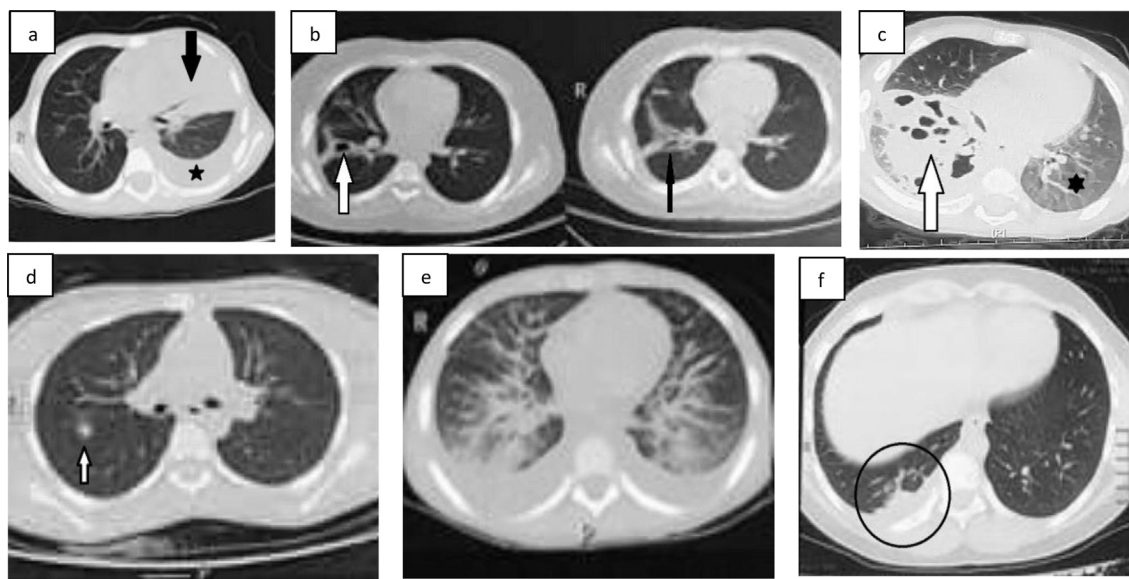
Atypical CT scan findings: a) complete lobar consolidation in left upper lobe (arrow) with left side pleural effusion (asterisk); b) A small cavity (arrow) with adjacent consolidation (thin solid arrow) in right lower lobe, c) A large area of cavitation/bronchiectasis with surrounding consolidation in right lower lobe (arrow). Diffuse ground glass opacity (asterisk) is seen in left lower lobe, which later progresses to air space opacity (not shown); d) A small nodule with surrounding ground glass halo in upper portion of pulmonary right lower lobe; e) Ground glass/patchy air space opacities are seen in bilateral lower lobes. Reticular opacities are also seen in lower aspects of the lungs, with bilateral pleural effusion; f) Mid pleural effusion is seen posterior to lower aspect of right lung with adjacent small parenchymal band/atelectasis in right lower lobe.
